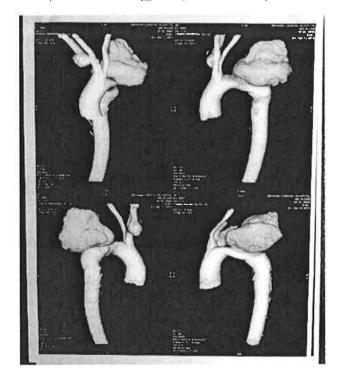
CT angiogram showing large saccular aortic arch aneurysm distal to the origin of left common carotid artery, which has mildly compressed the adjacent aortic arch and left common carotid artery. Also saccular aneurysm is seen in proximal right subclavian artery.
